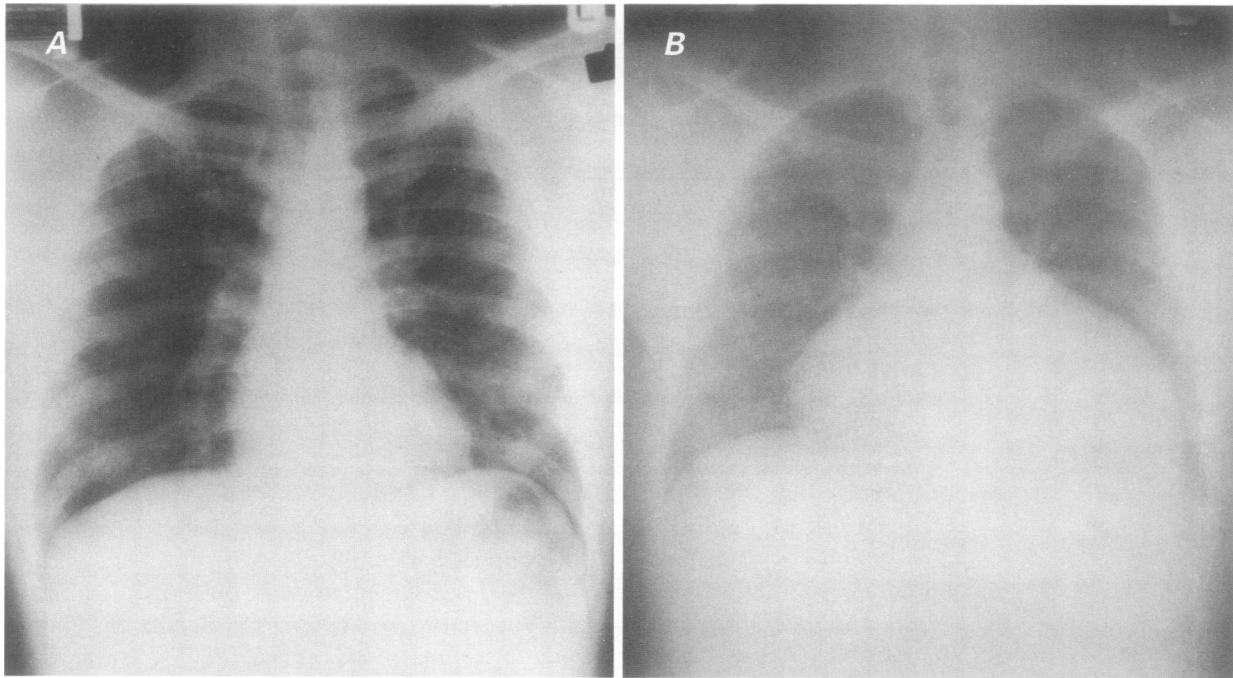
Chest radiographs showing A) normal cardiac size with mild pulmonary infiltrates and B) gross cardiomegaly.
